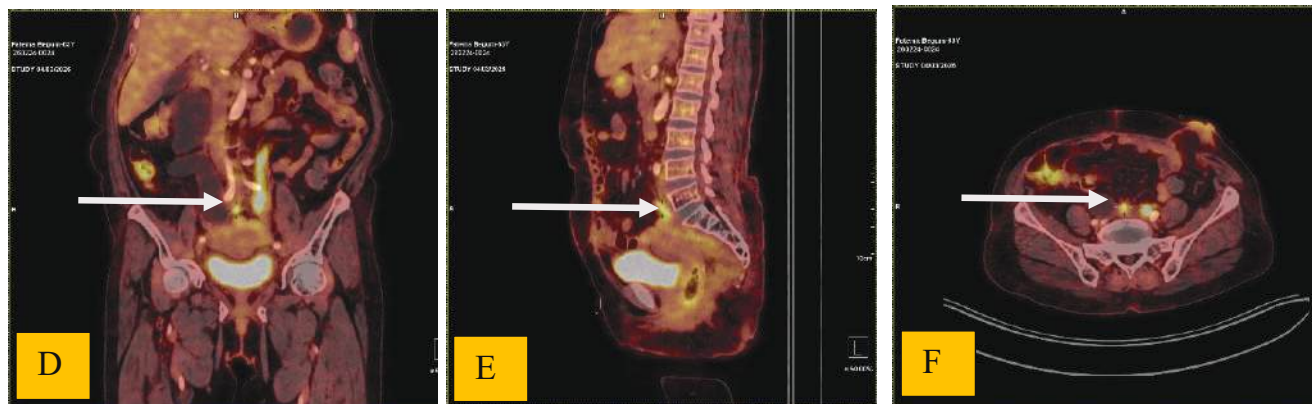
Fused PET/CT images (axial, coronal, and sagittal planes) demonstrate a focal area of hypermetabolic activity in the pelvic region (blue arrow) in figure: A, anatomically corresponding to the mid sacral vein (blue arrow) in figure C and figure E; suggestive of tumor thrombus.
